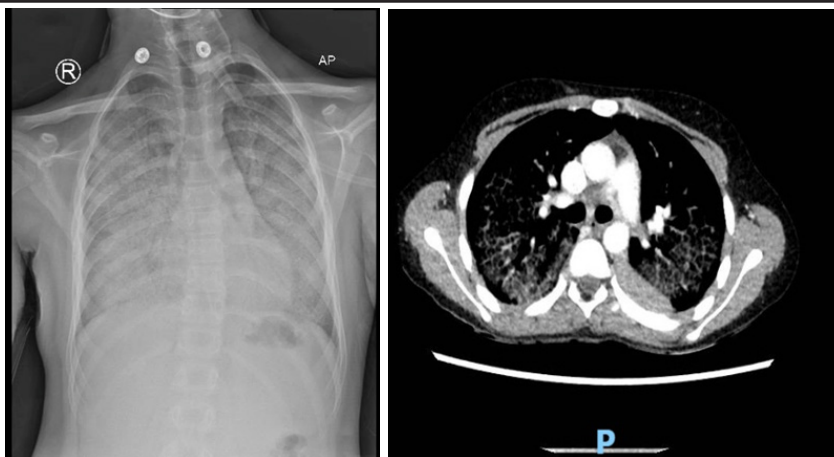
Initial Chest X ray and CT chest.
